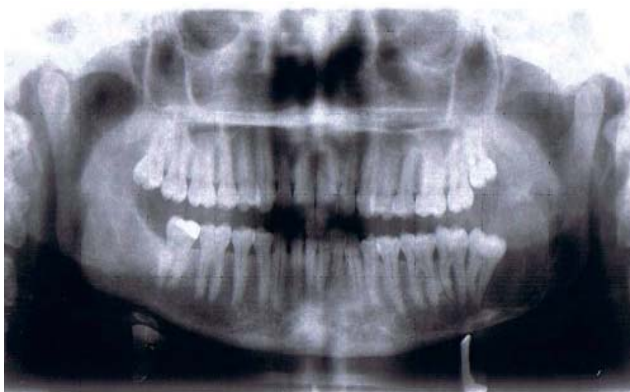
A panoramic radiograph shows a multilocular radiolucency in the left mandible (arrows).
